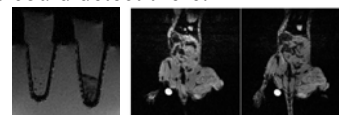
The MR imaging of target cells and in vivo model.
